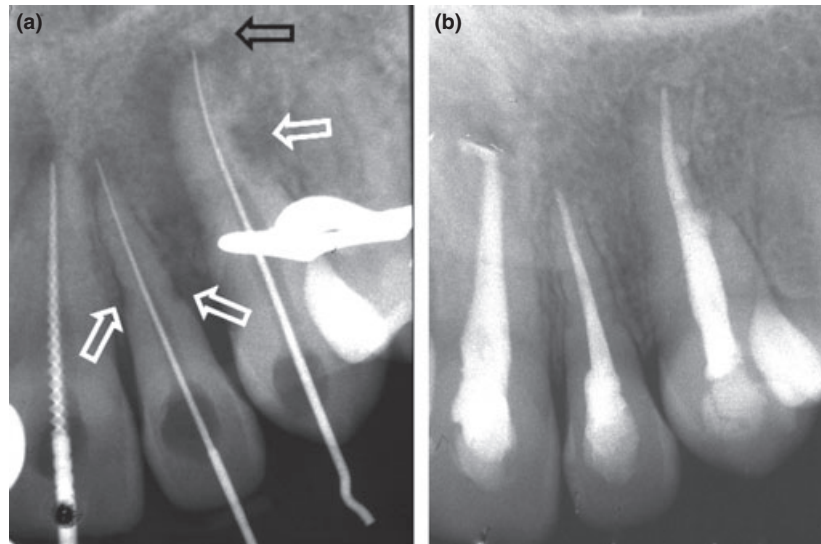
(a) Radiograph revealed inflammatory root resorptions (white arrows) and periapical radiolucent lesions. The fractured apex is displaced (black arrow). (b) Endodontic obturations. Note healing of the resorptive defects.
